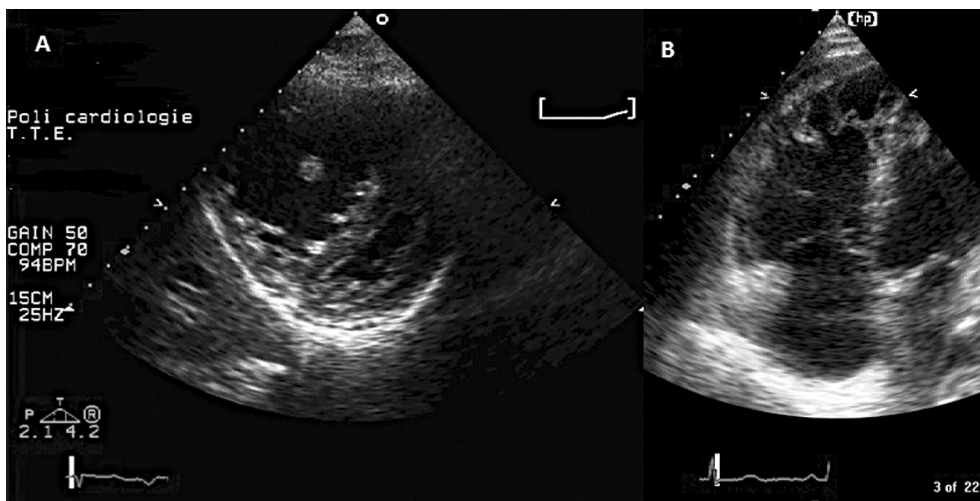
RV overload. These images were made in a 55-year-old woman suffering from severe pulmonary hypertension, due to chronic pulmonary embolism. Panel A shows an image obtained from the parasternal short axis view and panel B an image from the 4 chamber window. Note the dilated RV, that exceeds the LV dimensions, with rightward ventricular septal shift (*D Shape* of LV).
